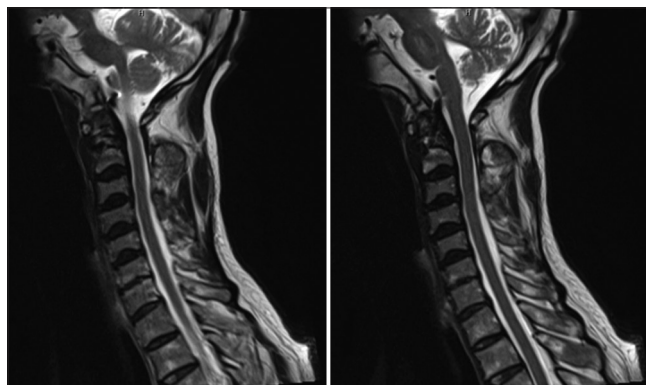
Sagittal magnetic resonance imaging sequences of the cervical spine demonstrating the odontoid screw lying within the ventral cervicomedullary junction.
